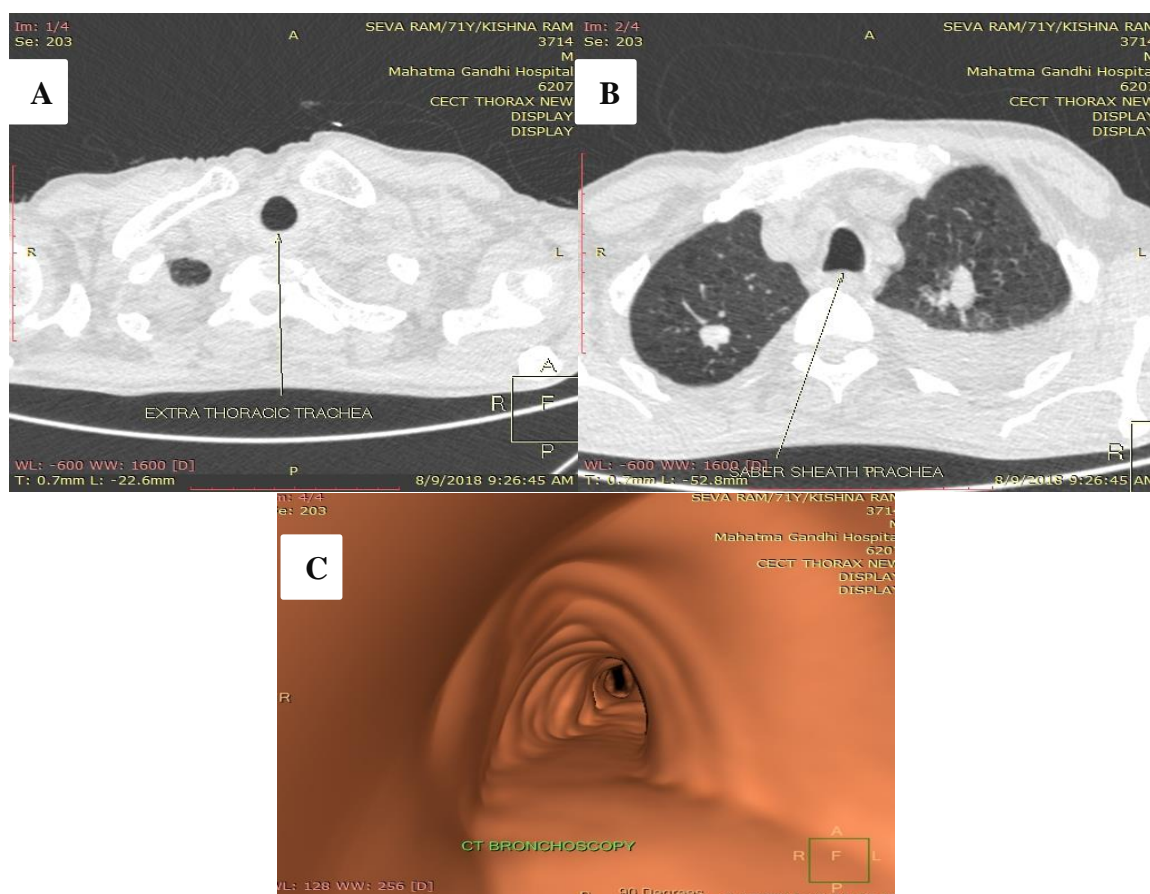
Axial CT-Thorax (A) demonstrate a normal extrathoracic trachea, (B) Another slides of the chest CT shows a saber- sheath intrathoracic trachea, (C) CT bronchoscopic view demonstrates Saber sheath trachea.
